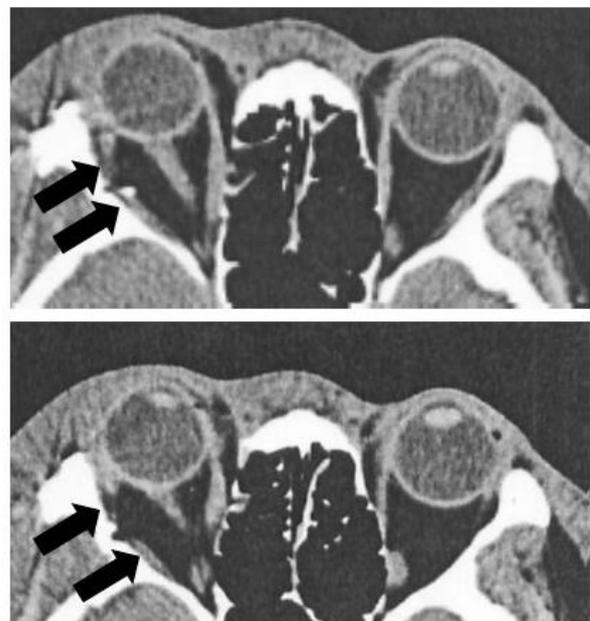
Preoperative computed tomography images of the patient
